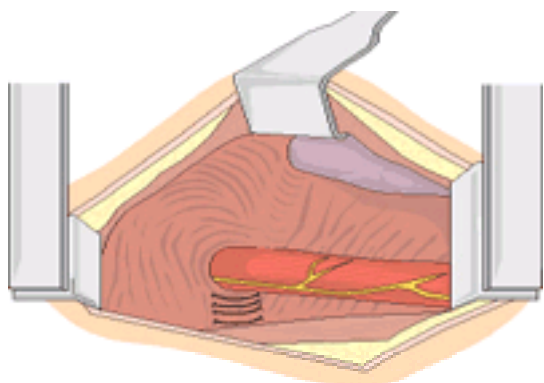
The completed transthoracic Nissen fundoplication. The repair is in the abdomen and the right and left crura have been approximated by tying the previously placed sutures.
